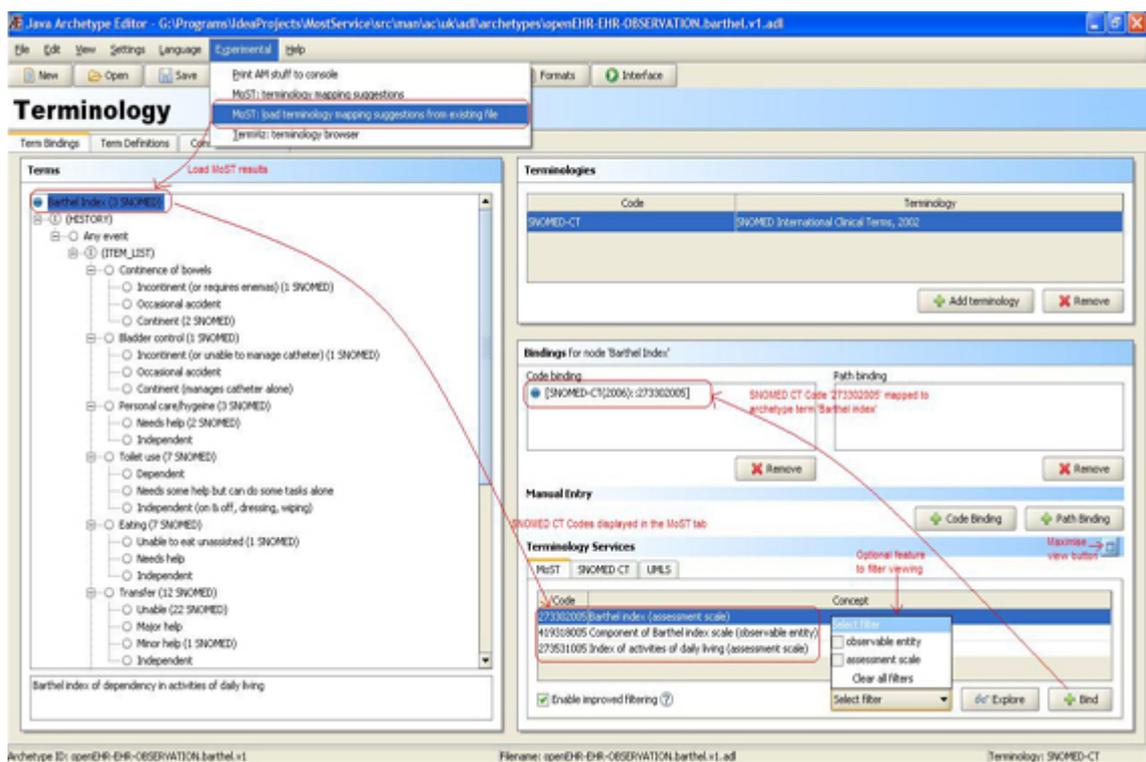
The MoST System integrated as a plug-in to the Archetype Editor: The *barthel index* model with a view of the MoST menu and SNOMED CT results.
